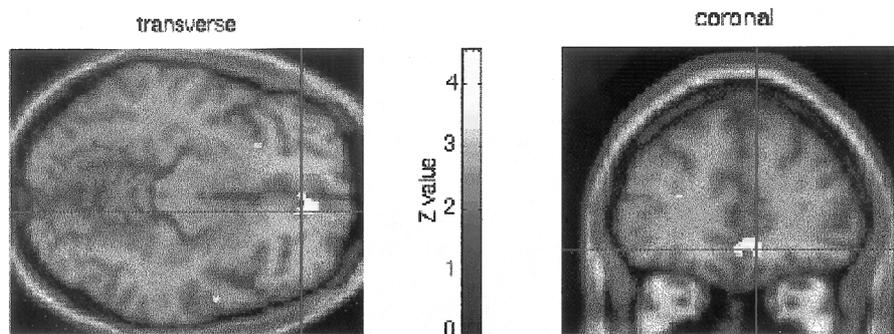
Activations associated with increasing task difficulty shows this activation rendered onto a standard MRI template and focused on the ventromedial orbitofrontal cortex.
